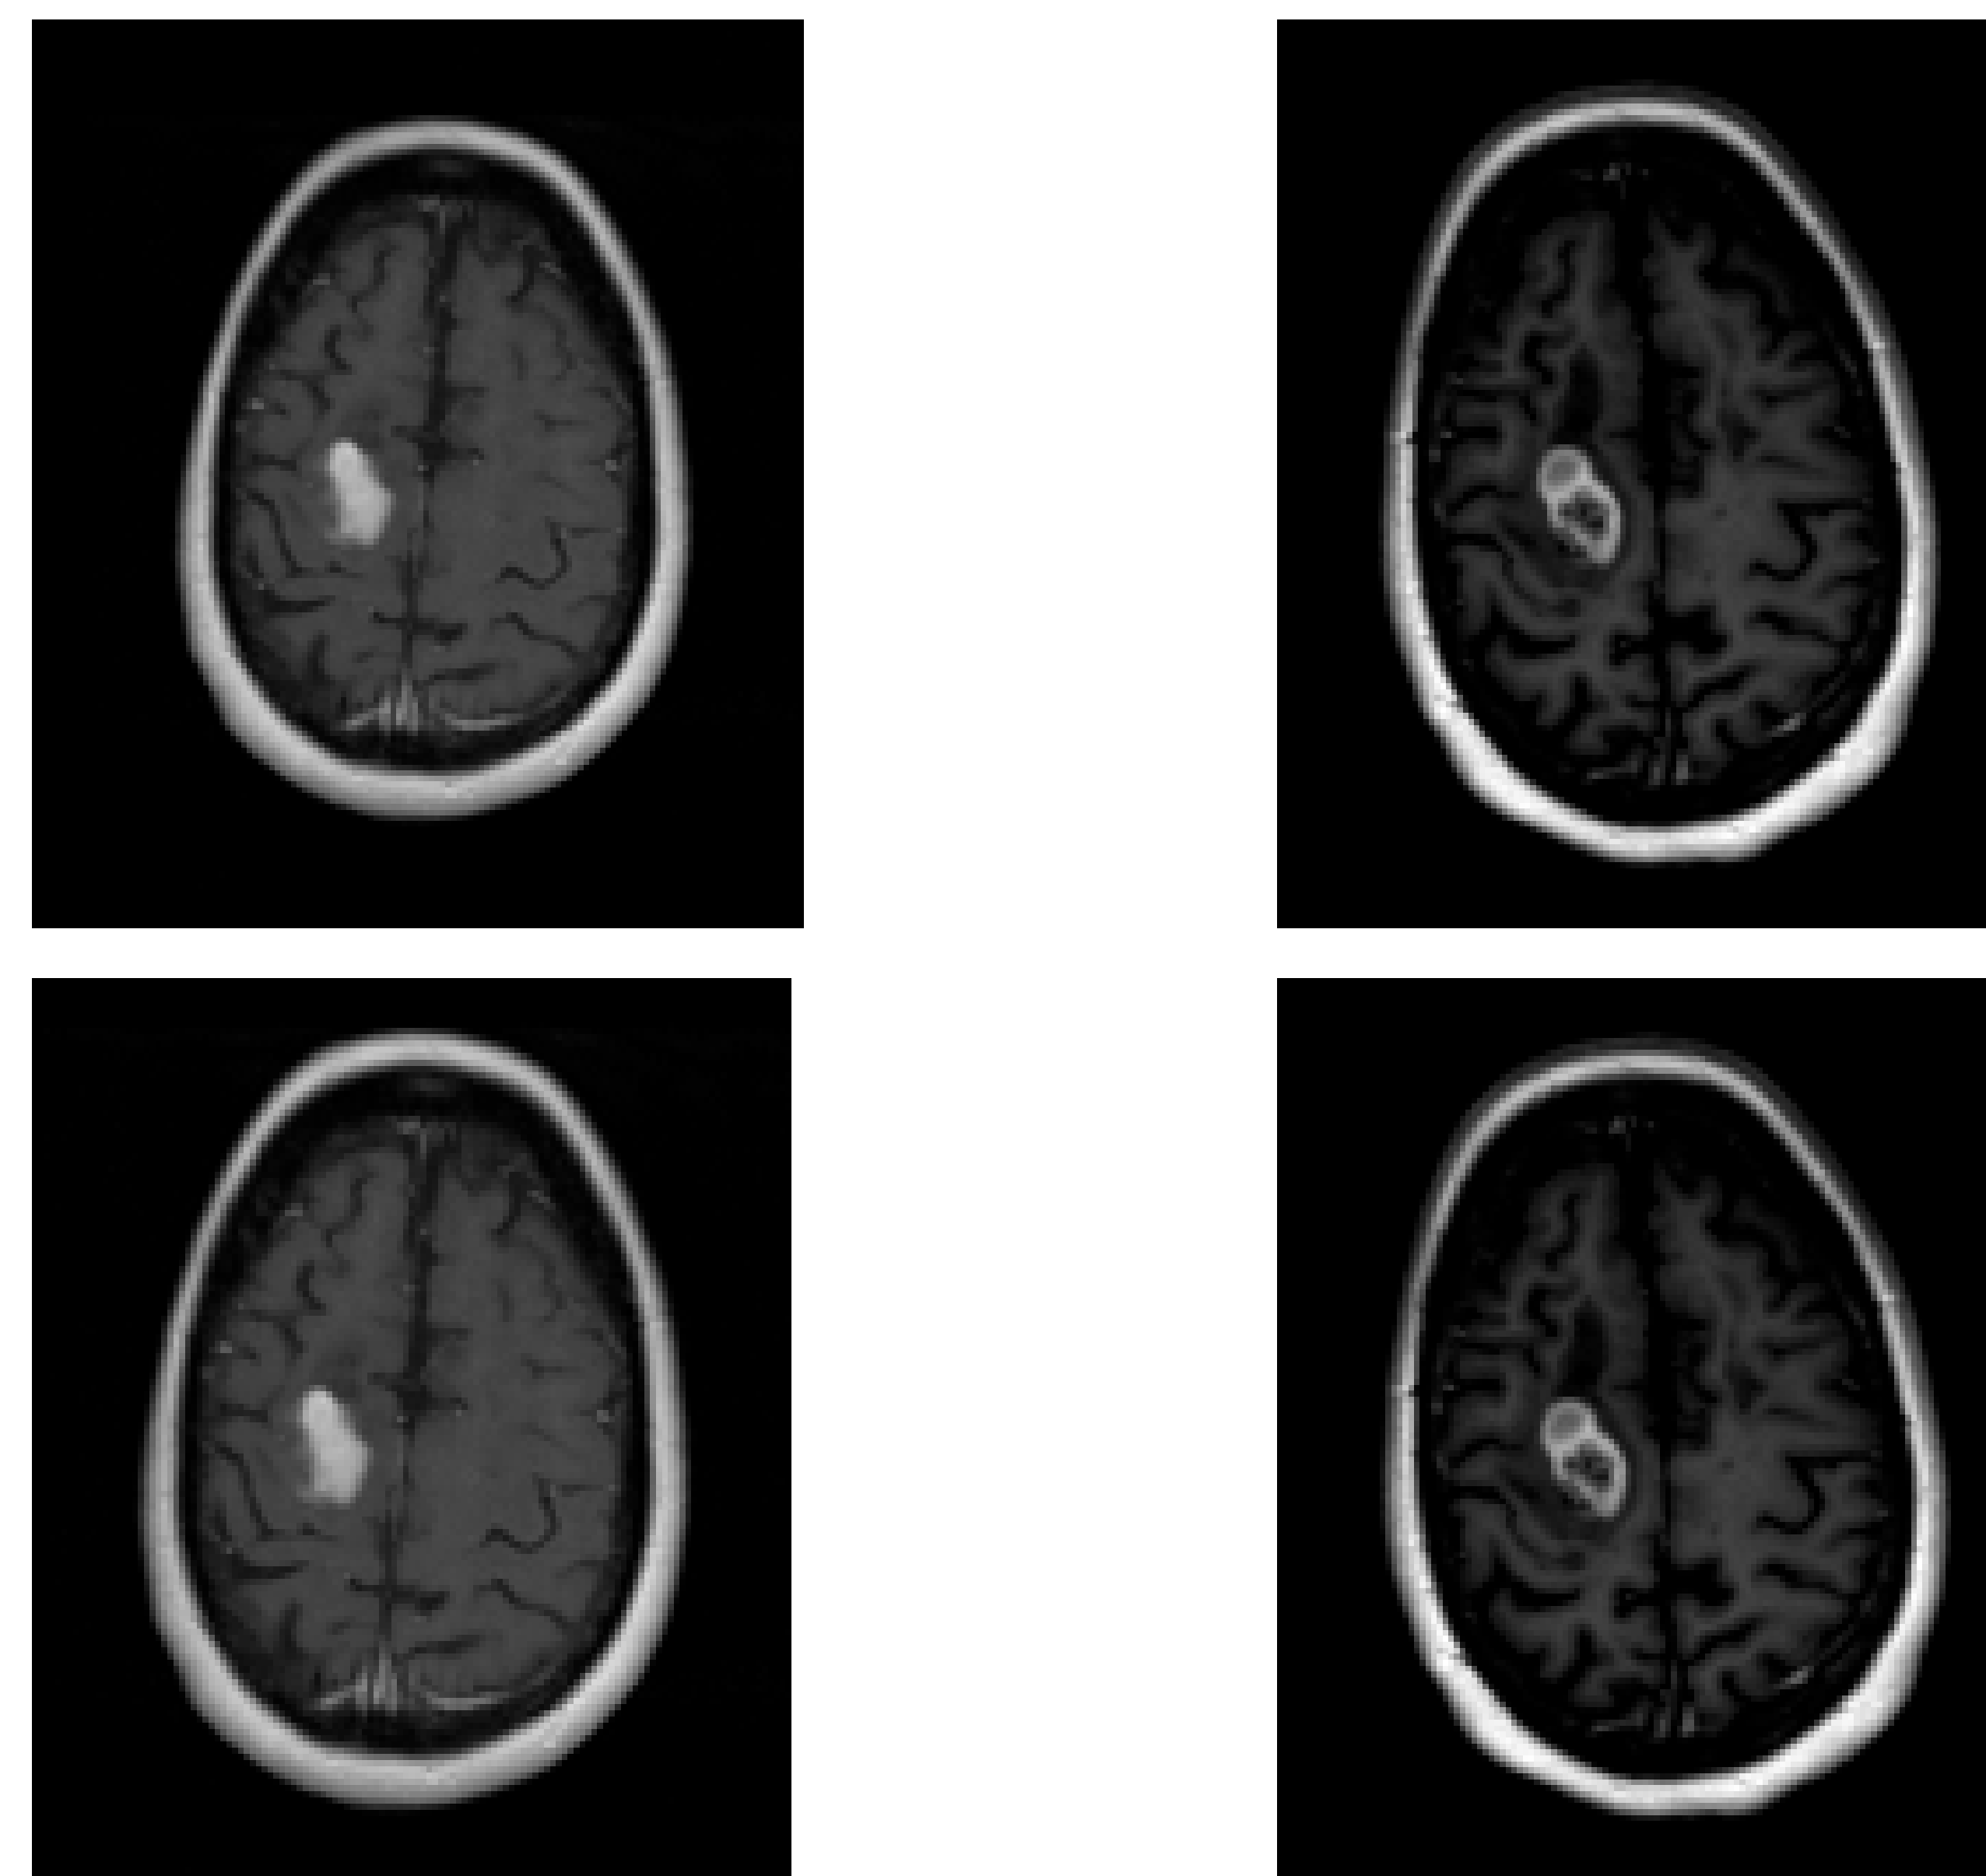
row 1: MRI T1 without contrast images
